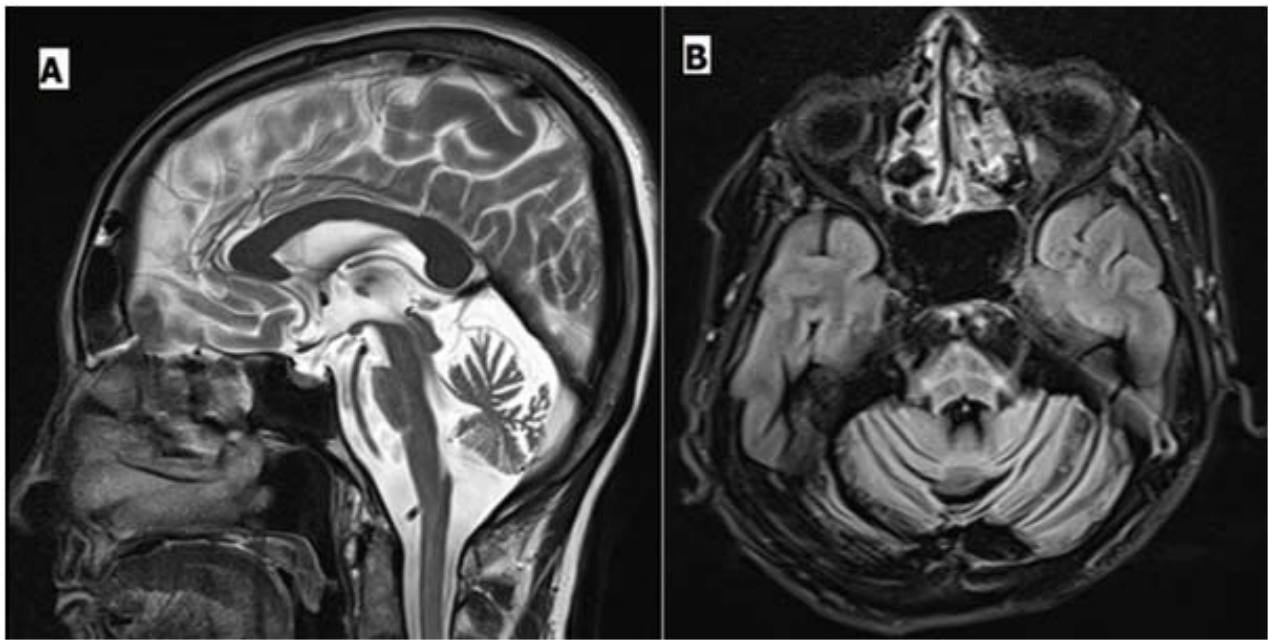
MRI brain T2 sagittal view showing pontine and cerebellar atrophy (A) and T2 axial FLAIR image view of the pons showing the “hot cross bun” sign (B).
